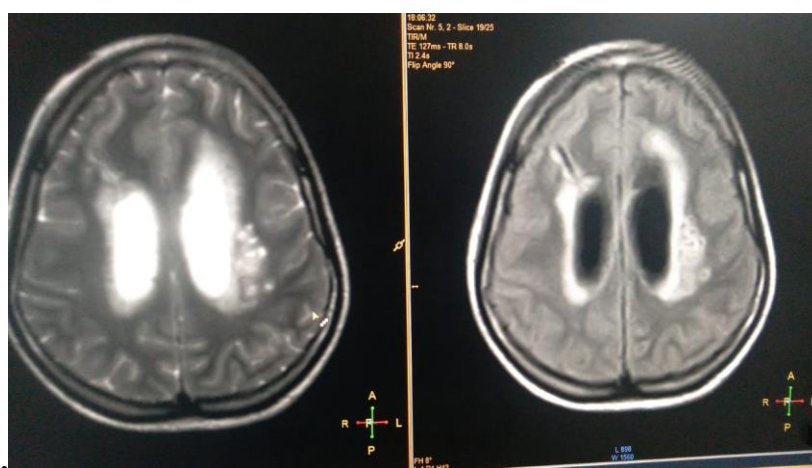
a.Axial T2 and b. Axial T2/FLAIR sequences showing effacement of sulcal spaces in bilateral cerebral hemispheres with linear FLAIR hyperintensities along sulcal spaces in bilateral cerebral hemispheres with communicating hydrocephalus and periventricular ooze. Also multiple rounded, well defined T2 peripherally hyperintense
